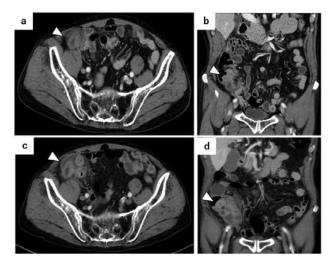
Enhanced abdominal computed tomography findings on admission and day 7 post admission.
